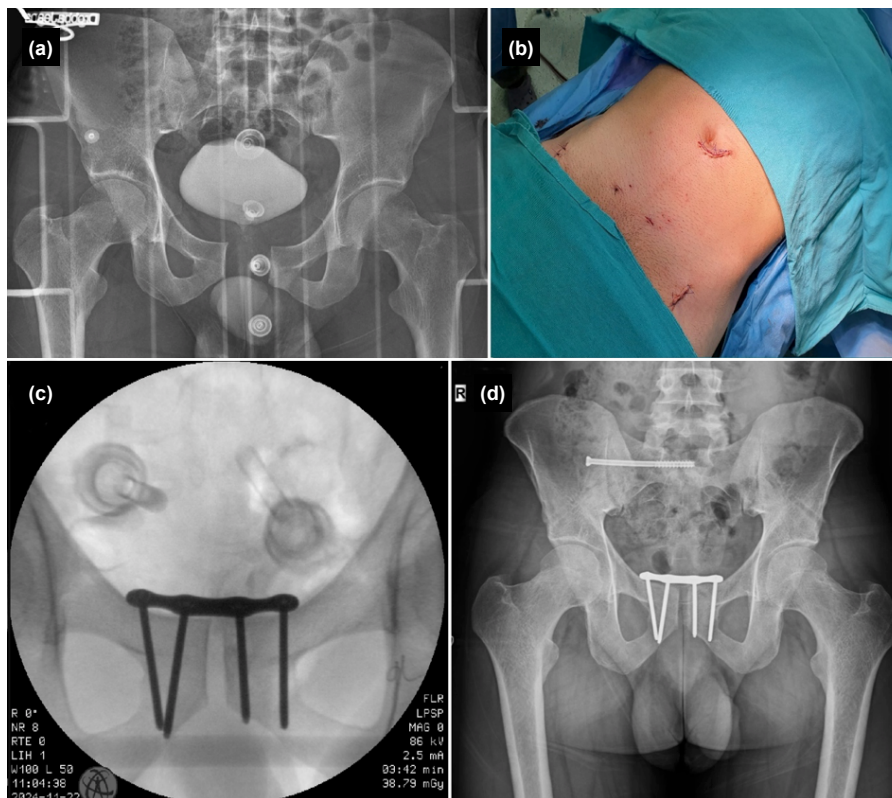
(a) Preoperative pelvis AP radiograph of a patient with an APC2 pelvic ring injury (Young-Burgess classification) and a B2-3D injury (AO/OTA classification); (b) Incisions used during the surgery; (c) Fluoroscopic check after the surgical procedure; (d) Postoperative 14th-month pelvis AP radiograph of the patient.
